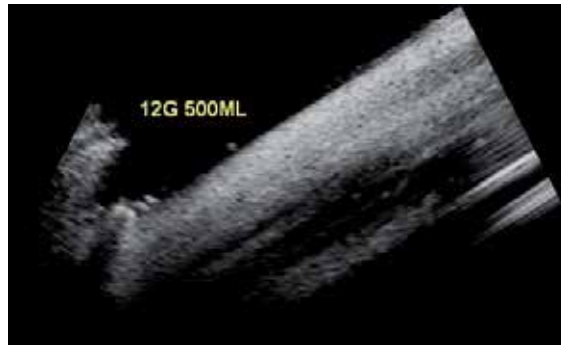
Enhanced ultrasound image of inflowing dialysate at $Q_D=500$ ml/min (Dialyser Altair 12G, US-machine Logic 7, GE Medical Systems, contrast agent: Optison®)
